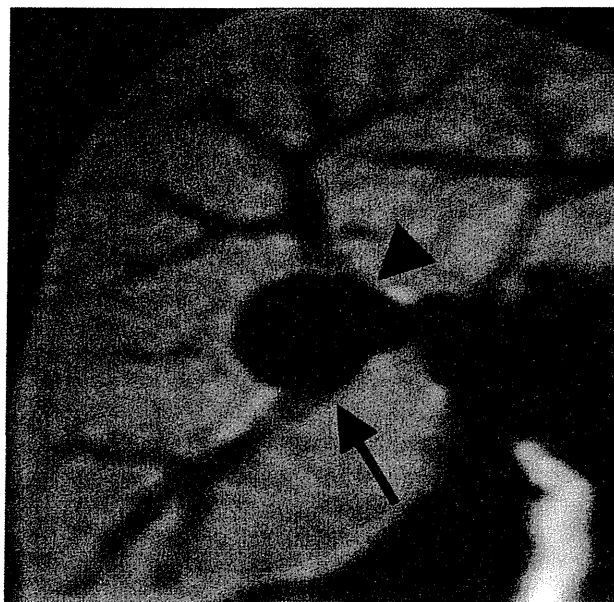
The coronal section view of magnetic resonance imaging (MRI) shows a cystic lesion at the confluence of the superior and inferior branches of the bile ducts of the anterior segment.
